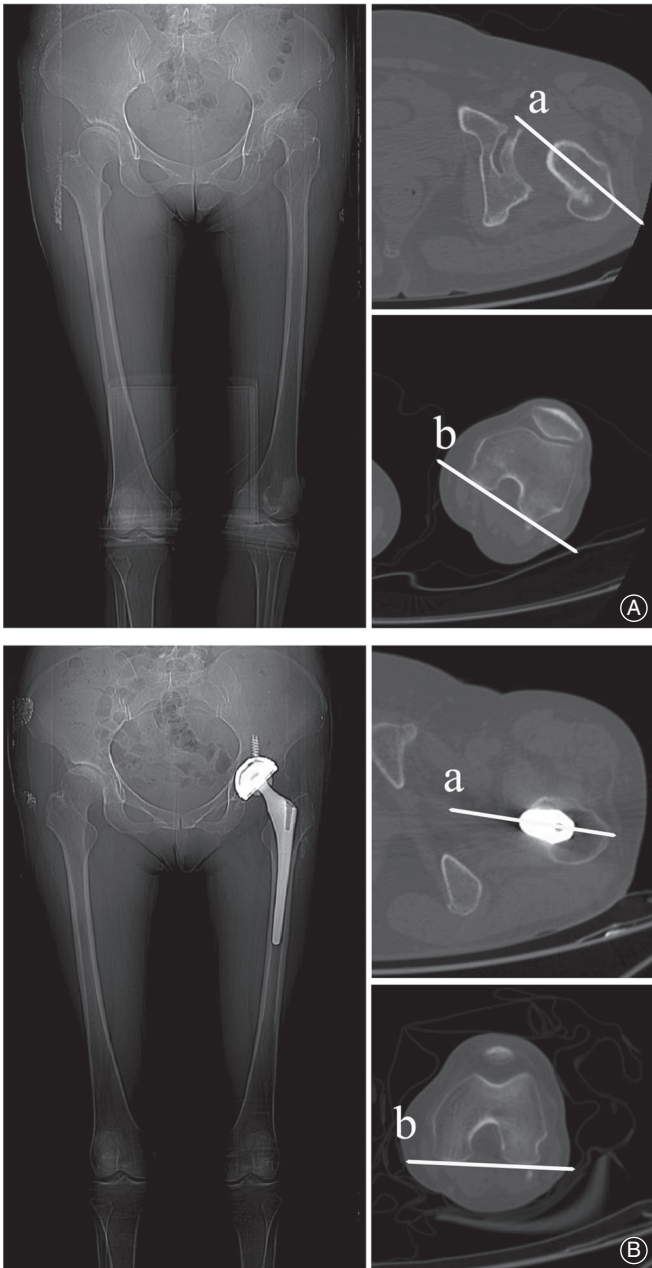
Measurements of the femoral anteversion angle on computed tomography (CT) scans. A, The anteversion angle was measured by the axis of the femoral neck (a) and a tangent to the posterior borders of the medial and lateral condyles (b) on preoperative CT scans. B, The anteversion angle was measured by the axis of the stem neck (a) and a tangent to the posterior borders of the medial and lateral condyles (b) on postoperative CT scans.
